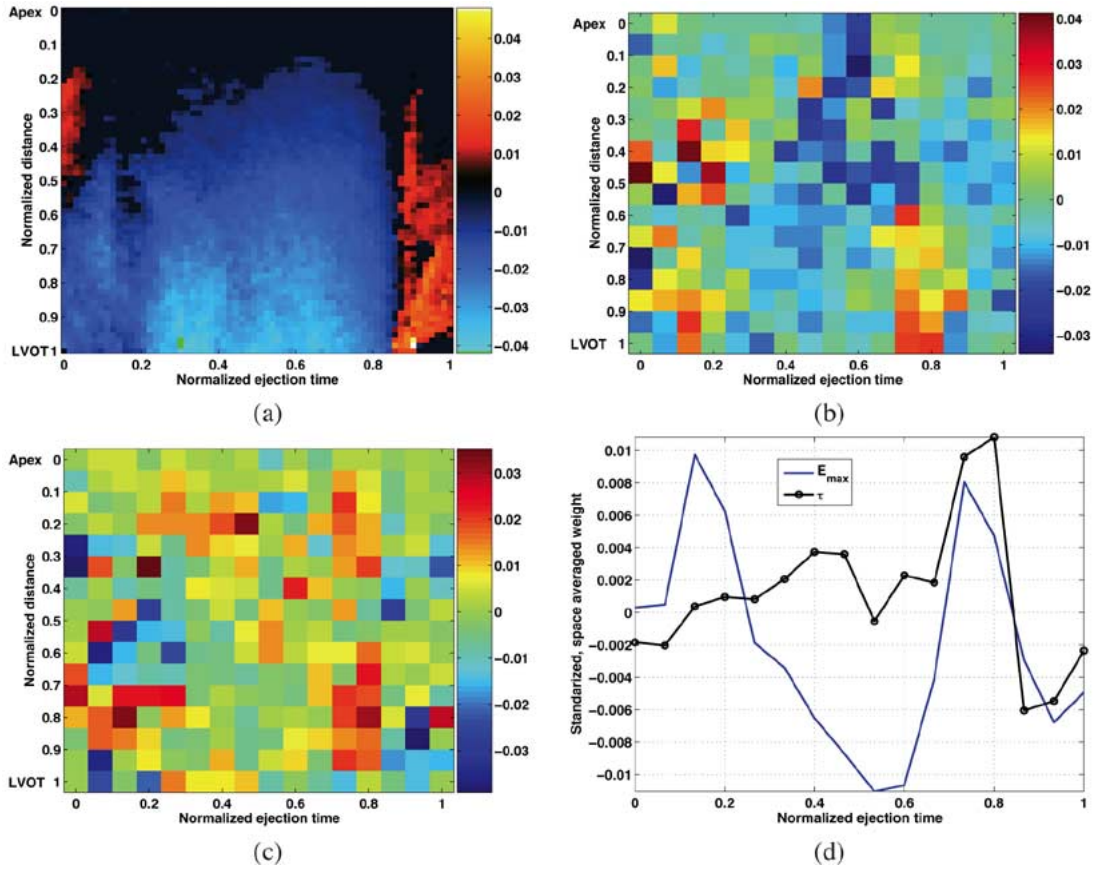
Linear SVM coefficients representation. (a) Example of centered and normalized Doppler M-mode image. (b) and (c) Map of standardized average coefficients for E_{\max} and τ regression models, respectively. (d) Space-averaged standardized coefficients.
